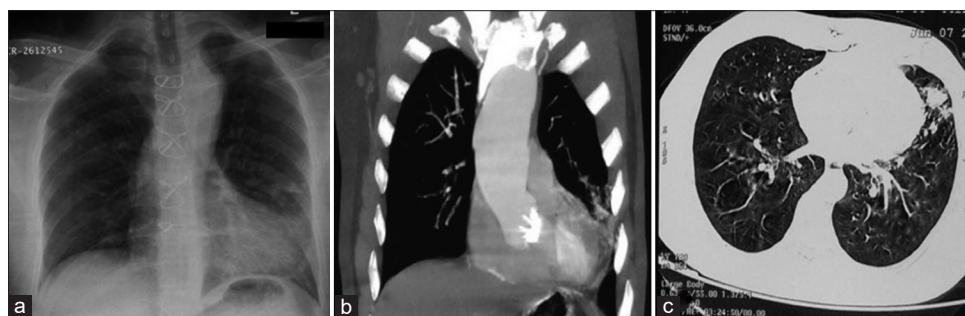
(a) Plain radiograph of the chest shows a focal patchy peripheral area of consolidation in the left middle zone. Note made of sternal suture. (b) Maximum intensity projection coronal image and (c) axial image of the thorax show focal area of consolidation in the lingula. There is also aneurysmal dilatation of the ascending aorta
